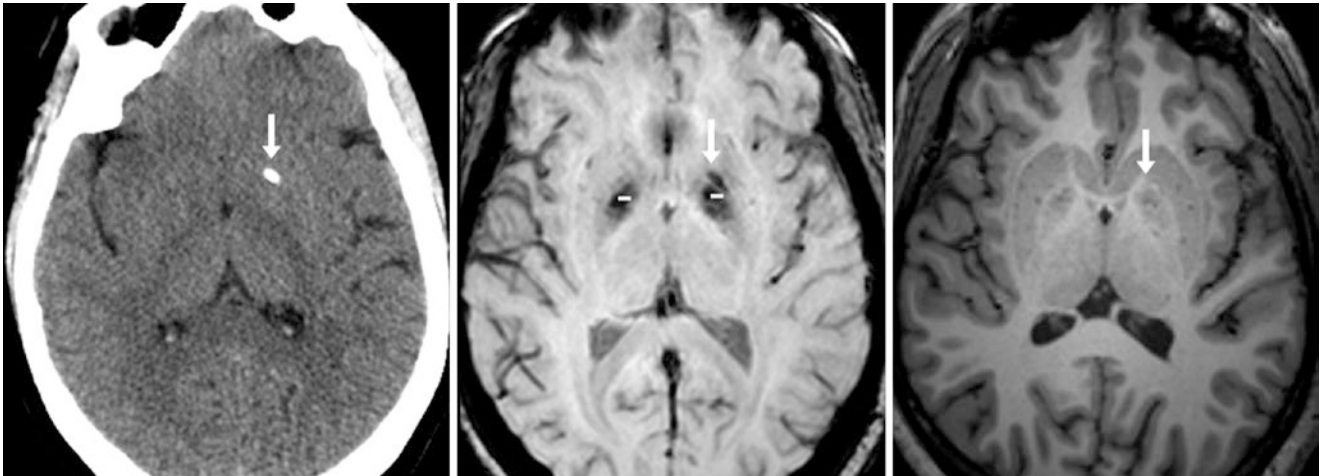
A 28 year old with a prominent left BG calcification (arrows) on NECT (left) and on 3T SWI MRI (middle). Note that on SWI, the regions of the bilateral iron deposits (–) are much larger than
